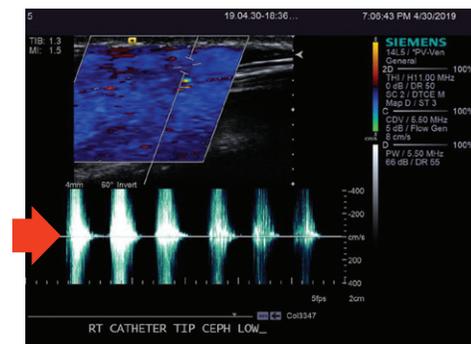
Example of a Vascular doppler Image with duplex measurement of a right forearm with a catheter placed in the lower cephalic vein. The arrow shows the blood flow velocity measured in frequency (cm/sec).
